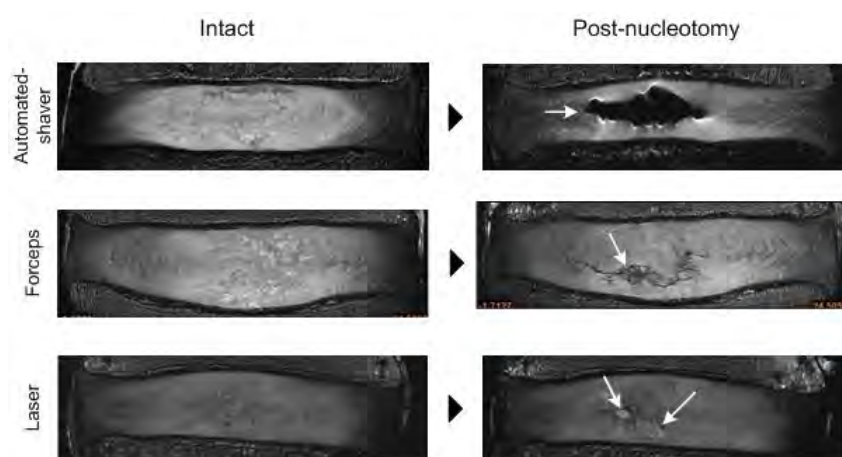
Left column shows intact MRI, and right column shows post nucleotomy MRIs. White arrows have been added to facilitate the identification of cavities
